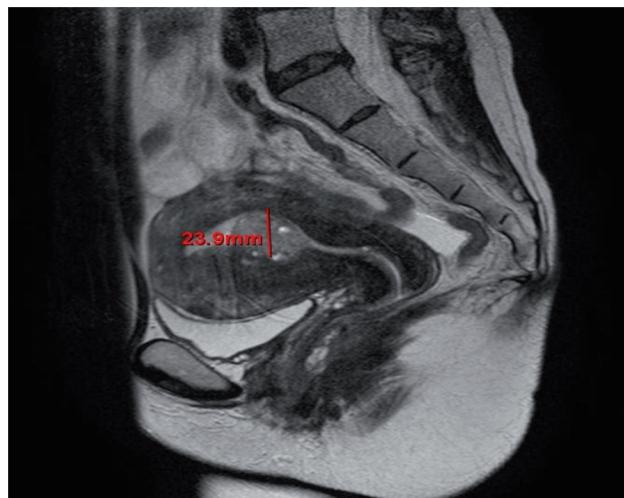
MRI of the endometrium before MEA. T2-weighted imaging revealed an endometrial polyp (23.9 mm) in the uterus.
